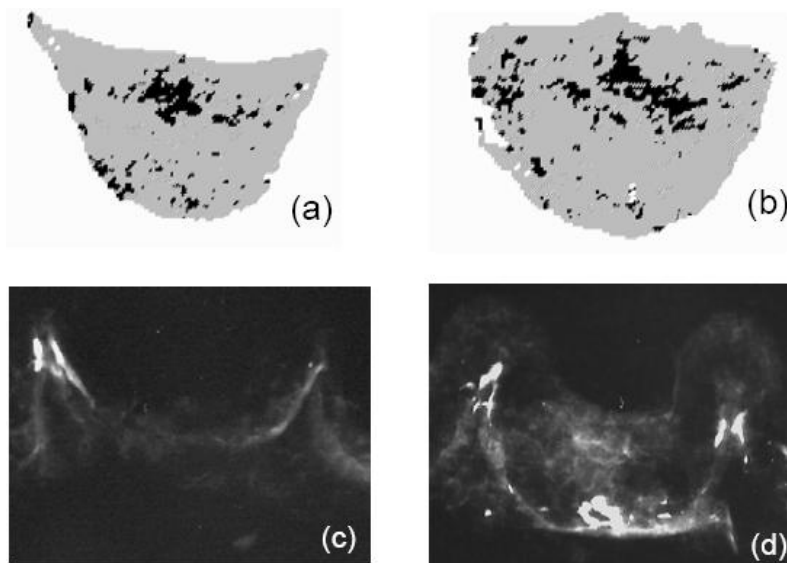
(a, b) Areas of damaged collagen and calcification in explanted valve imaged using SALS, (c, d) X-ray image of the valve cusps showing calcification
